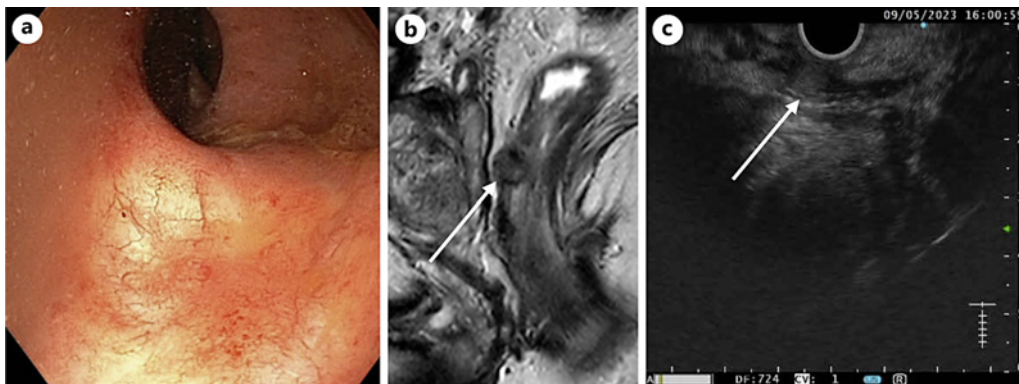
a, b, c Endoscopy, MRI, and EUS-FNA images of suspected regrowth in the bowel wall, which is endoscopically not visible.
